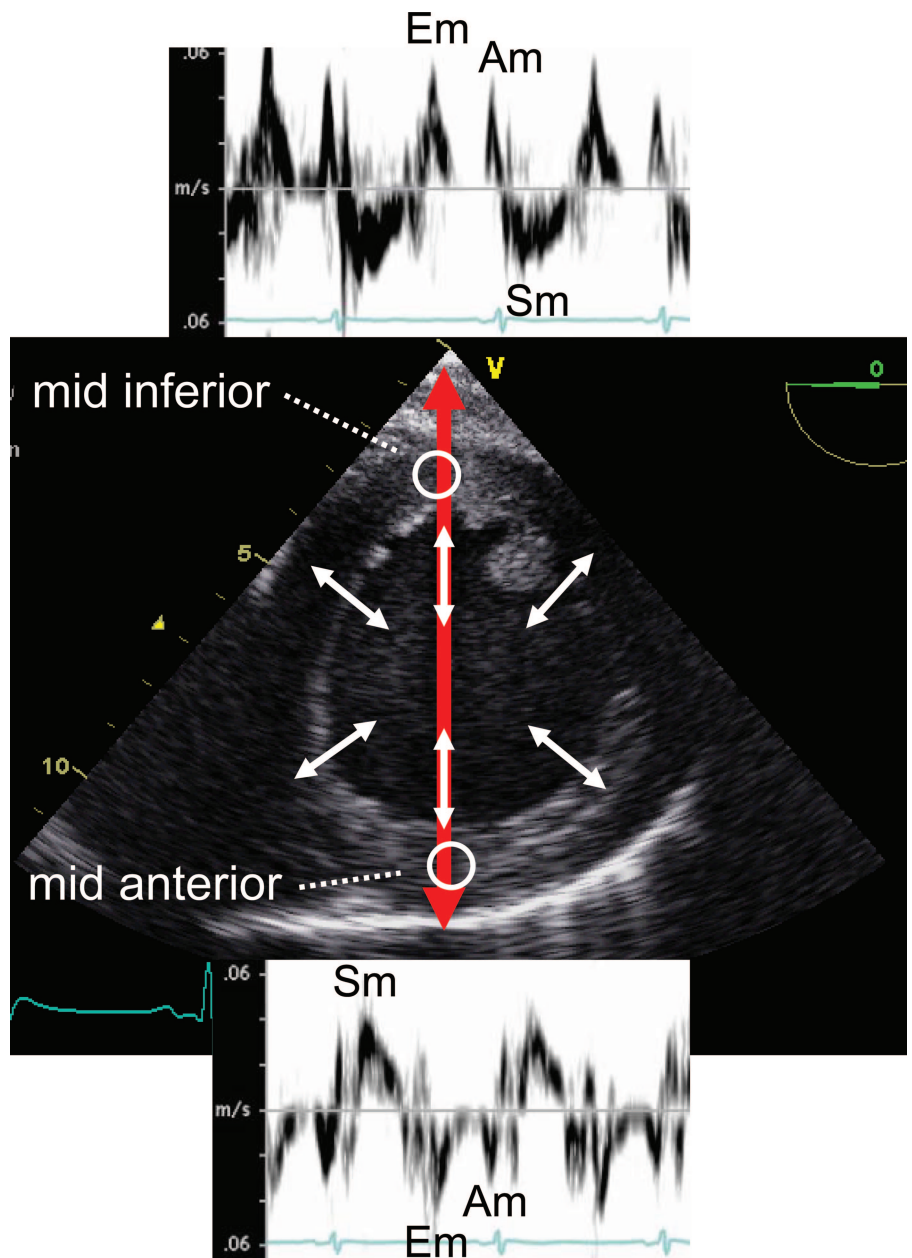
Transverse myocardial velocities (spectral Doppler tissue imaging [DTI]) recorded from sample volumes (white circles) positioned in the center of the left ventricular mid inferior (top) and anterior (bottom) segments (transgastric mid short axis view). The segmental motion during systolic thickening and diastolic thinning is in opposite direction, hence the mirror image of velocities. DTI from the septal and lateral segments is not possible because of increased angle between Doppler (red arrow) and direction of wall motion (arrows). Sm = systolic myocardial velocity; Em = early diastolic myocardial velocity; Am = late diastolic myocardial velocity.
